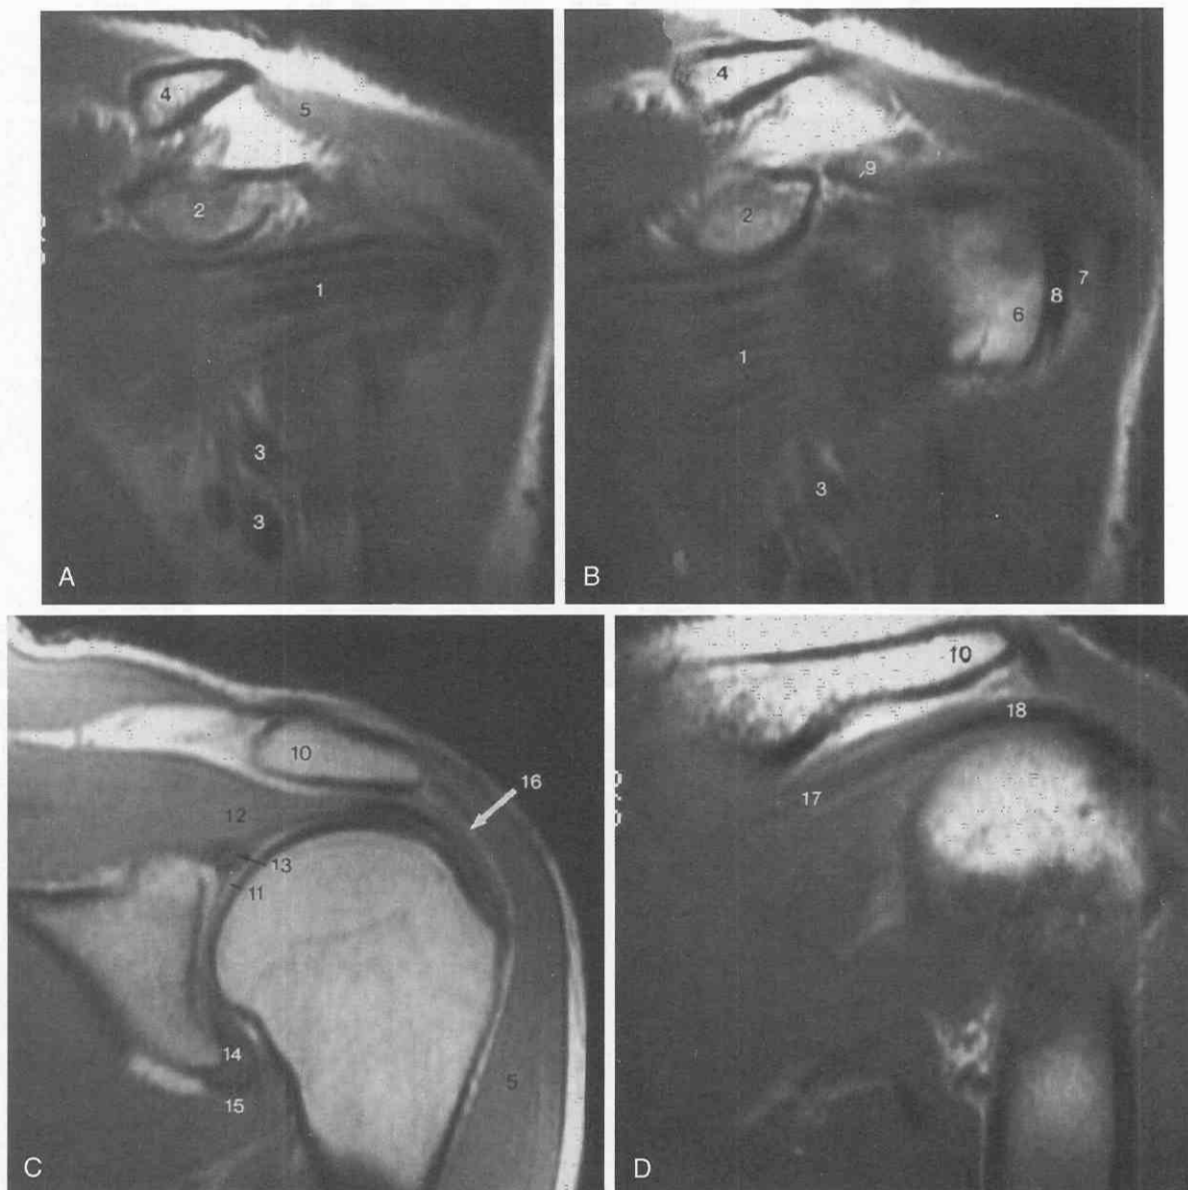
A-D, MRI coronal oblique views of the shoulder (see text for details). 1, subscapularis muscle; 2, coracoid process; 3, axillary vessels; 4, clavicle; 5, deltoid; 6, lesser tuberosity; 7, greater tuberosity; 8, bicipital tendon; 9, coracohumeral ligament; 10, acromion; 11, humeral articular cartilage; 12, supraspinatus muscle and tendon; 13, superior labrum; 14, inferior labrum; 15, inferior glenohumeral ligament/axillary recess; 16, fat stripe; 17, infraspinatus muscle; 18, infraspinatus tendon.
